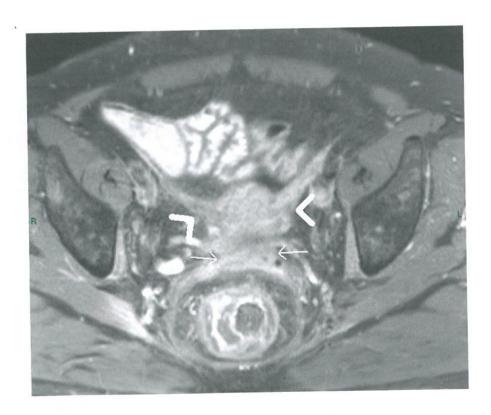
Gadolinium-enhanced fat-saturated T1-weighted axial cross-section. Spread of tumor tissue to the vagina (arrows) and parametrium is well depicted (arrow heads).
